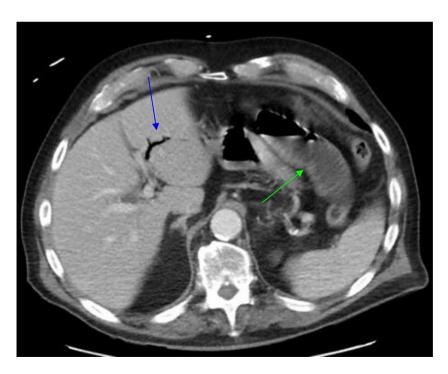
CT Abdomen and pelvis with IV contrast, axial view. The blue arrow indicates pneumobilia, signifying the presence of air within the biliary tree. The green arrow points to dilated loops of the small bowel, indicative of small bowel obstruction.
